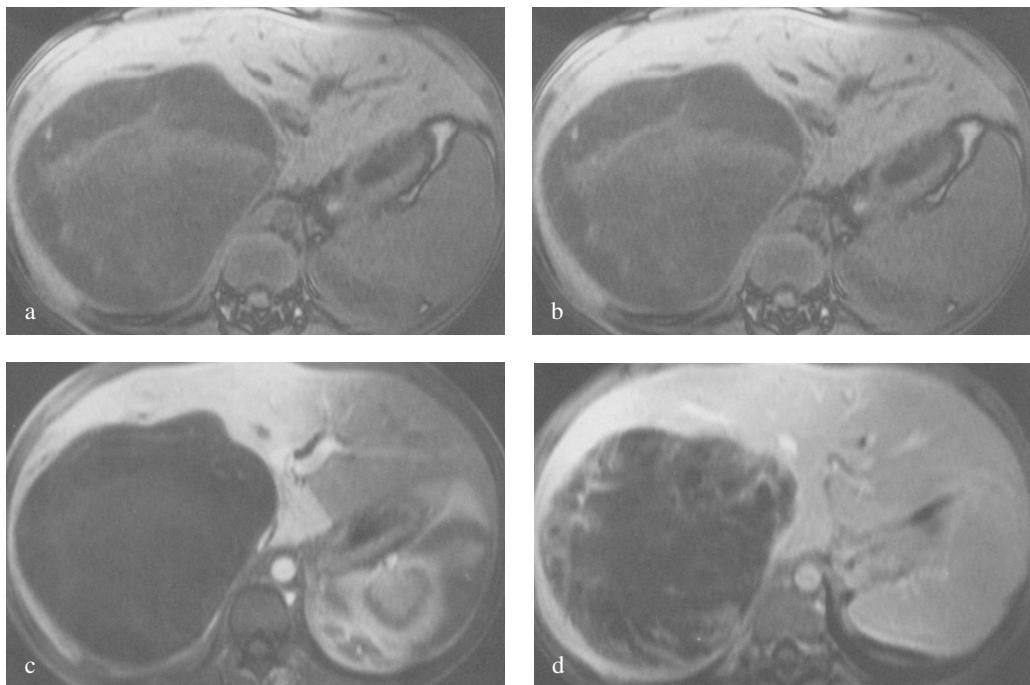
[13] – Undifferentiated embryonal sarcoma: a) coronal T2-weighted fat-sat suppressed show a large mass in high signal; b) axial T1-weighted without contrast; c) T1 weighted images after contrast images show in early phase a negligible enhancement; d) late-phase - moderate enhancement of the outer margins of the mass.
